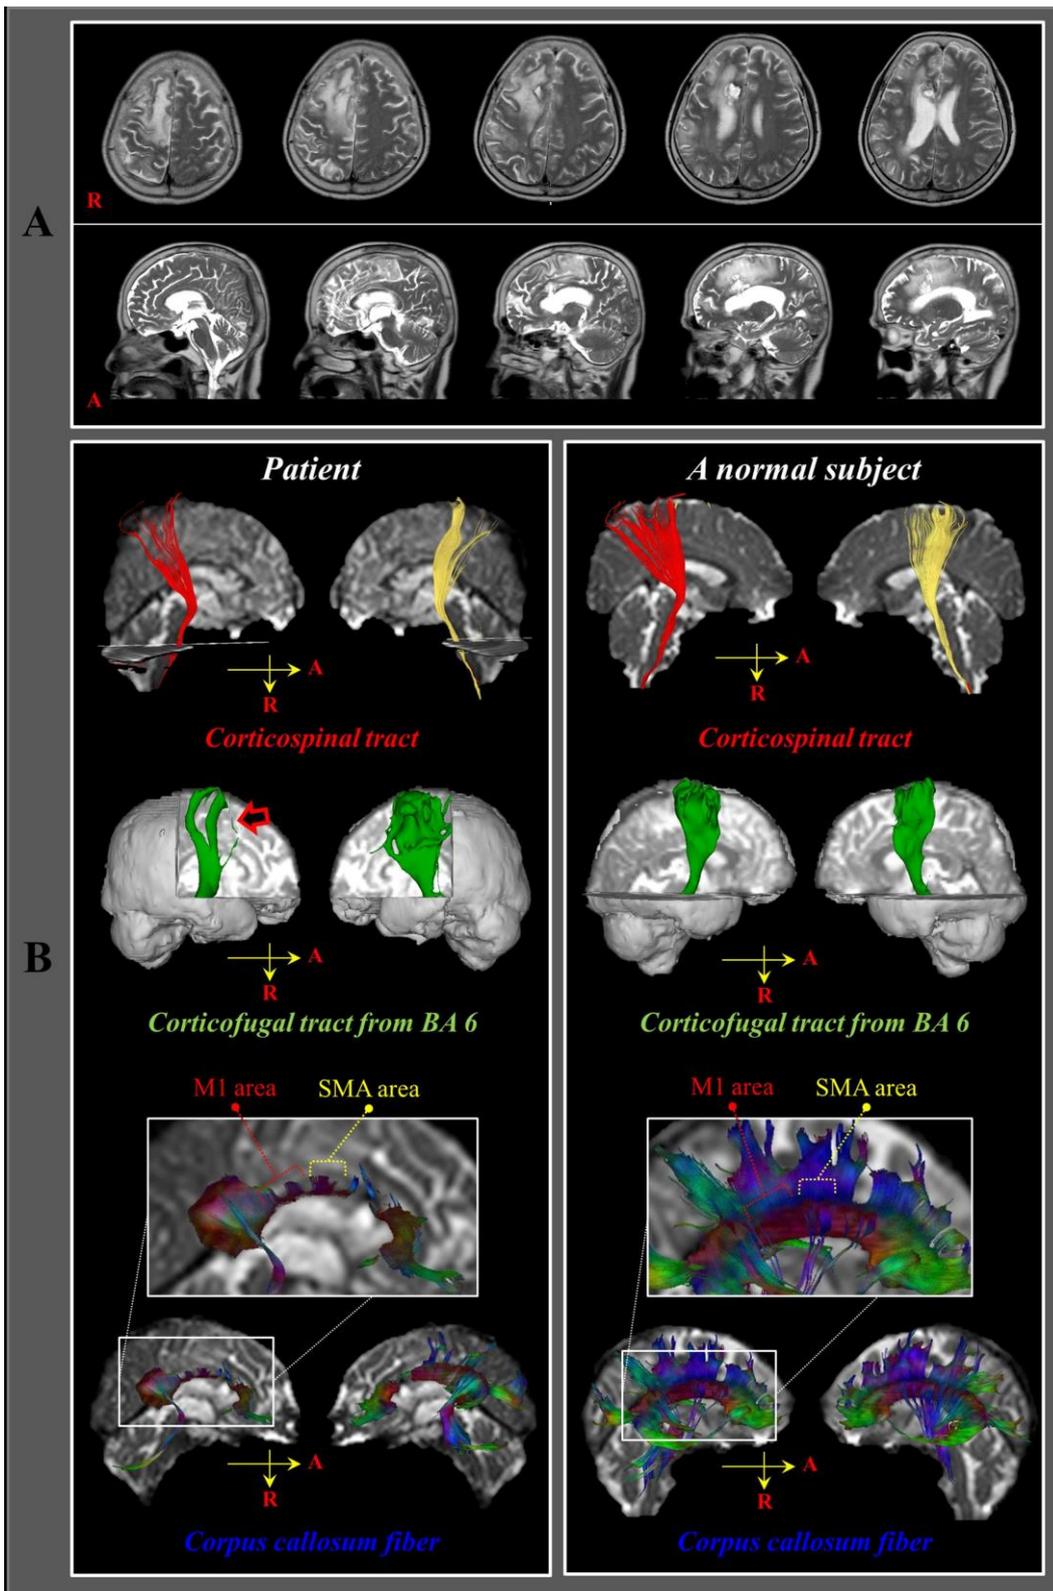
(A) T2-wrighted MR images at three weeks after onset show intracerebral hemorrhage in the right prefrontal cortex and corpus callosum (arrows). (B) On two-month diffusion tensor tractography, the integrity of the corticospinal tract is preserved in both hemispheres. However, narrowing and partial tearing (arrow) is observed in the right corticofugal tract from the secondary motor area (SMA) compared with a normal subject (55-year old female). Injuries of the corpus callosum fibers from the primary sensori-motor cortex (SM1), SMA, and prefrontal cortex in both hemispheres are observed.
